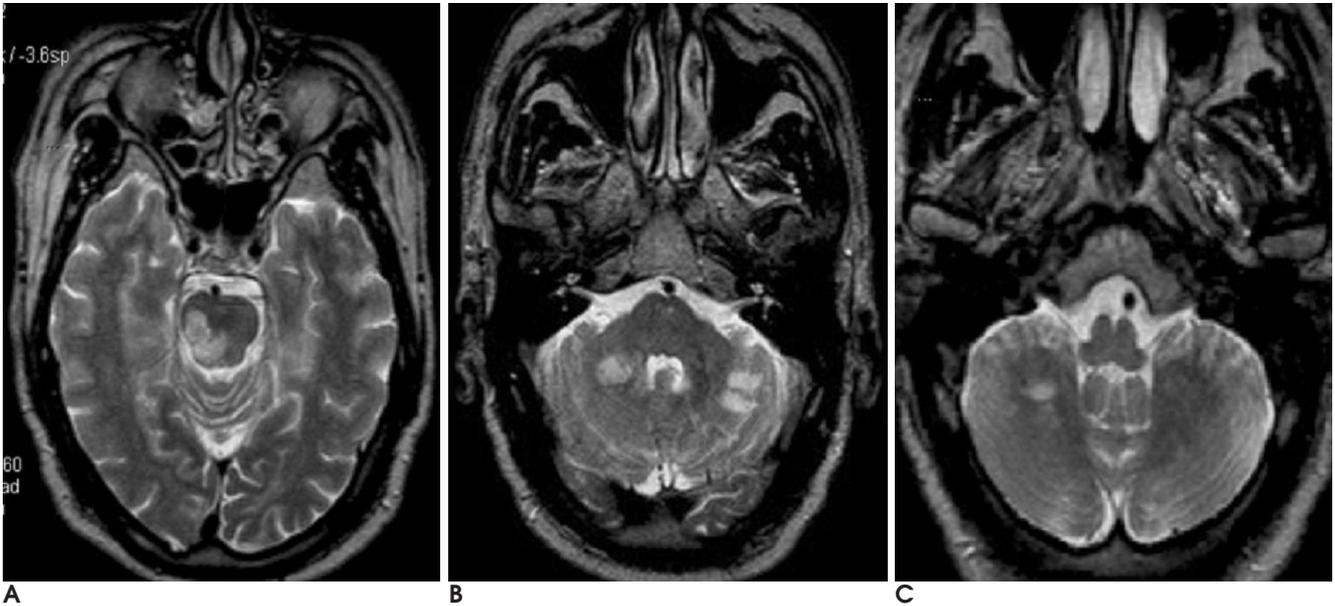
A 59-year-old man with left side weakness. A, B. T2-weighted axial image shows high signal intensity at the right brainstem and dentate nucleus, left cerebellar hemisphere. C. T2-weighted axial image shows no abnormal signal intensity or size change in medulla oblongata.
